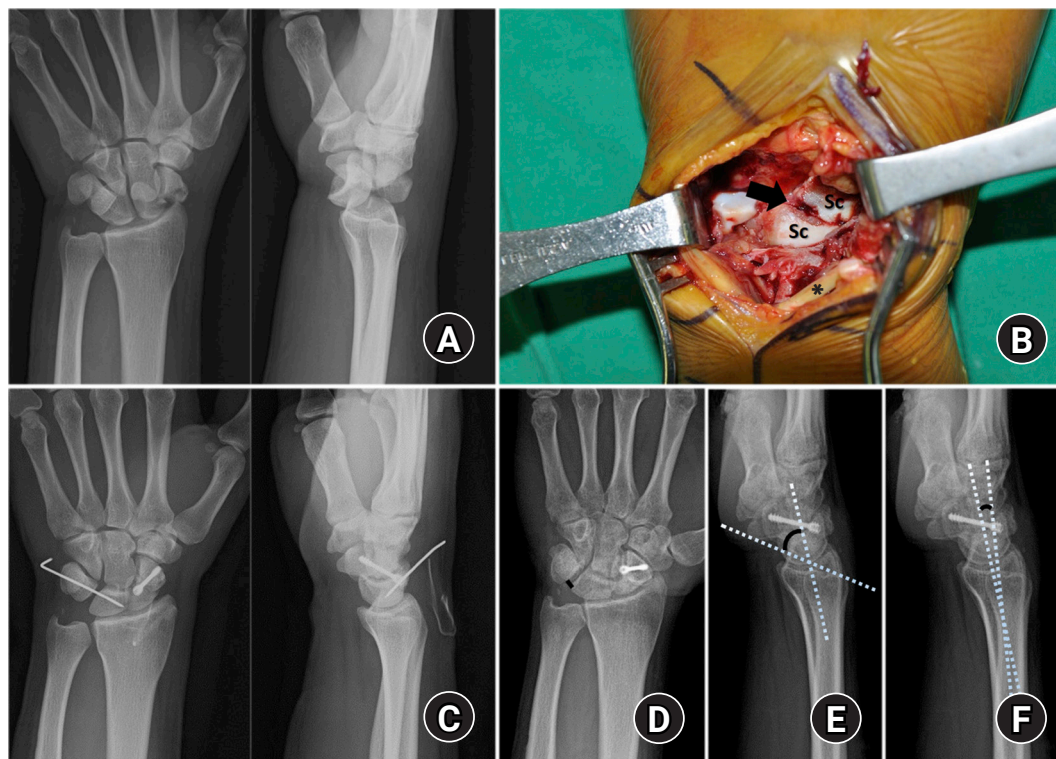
Open reduction and fixation for trans-scaphoid perilunate fracture dislocation (PLFD). (A) Posteroanterior and lateral views of the preoperative radiographs of a 46-year-old man showing a dorsal trans-scaphoid PLFD of the left wrist. (B) Approaching on the dorsal aspect of the wrist, the extensor pollicis longus tendon (asterisk) is retracted radially, and the scaphoid (Sc) fracture is shown with a displacement (arrow). Sc, scaphoid. (C) The postoperative radiographs show proper fixation and normal carpal alignment. (D-F) The radiological measurements after 2 years postoperatively identify 2.0 mm of lunotriquetral distance (D), 56.0° of scapholunate angle (E), and 4.6° of radiolunate angle (F). Reprinted from Oh et al. [60] with the permission of Elsevier.
